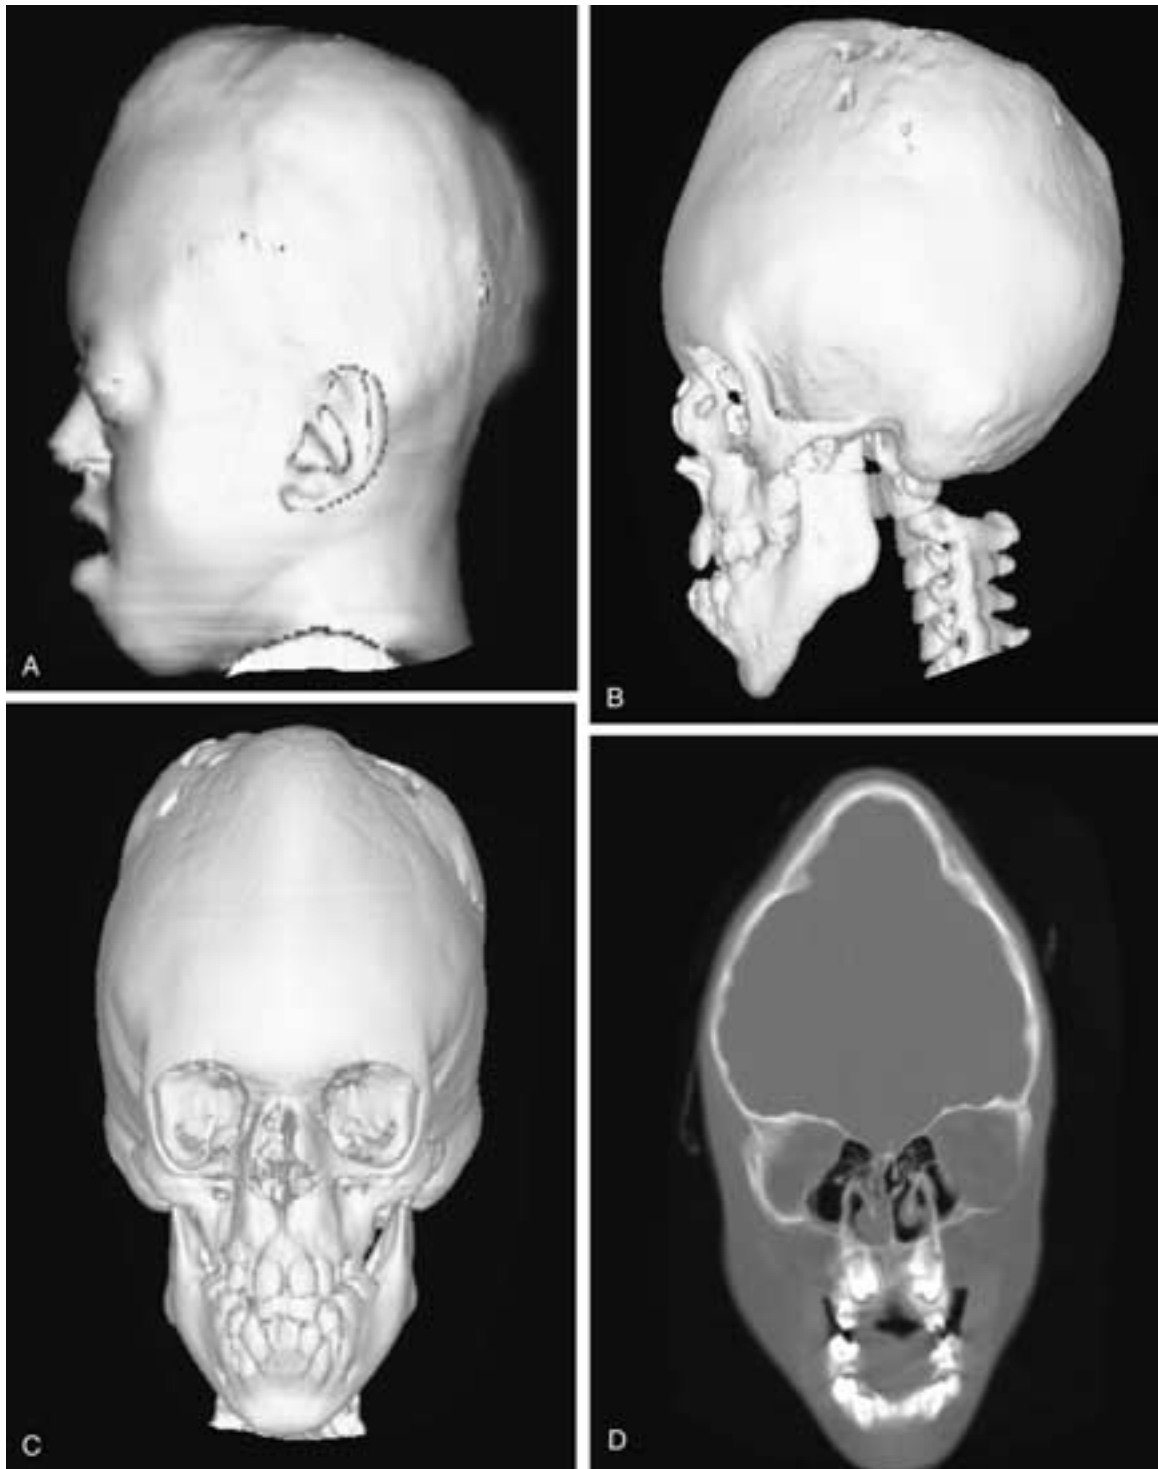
Crouzon syndrome in a 9-year-old girl. A to C, Three-dimensional CT of the lateral skin surface (A), the lateral facial skeleton (B), and the frontal facial skeleton (C). D, Direct coronal CT. The patient shows oxycephaly, shallow orbits with exorbitism, hypoplasia of the midface with narrow, partially obstructed nasal passages, relative prognathism, and an everted lower lip.
